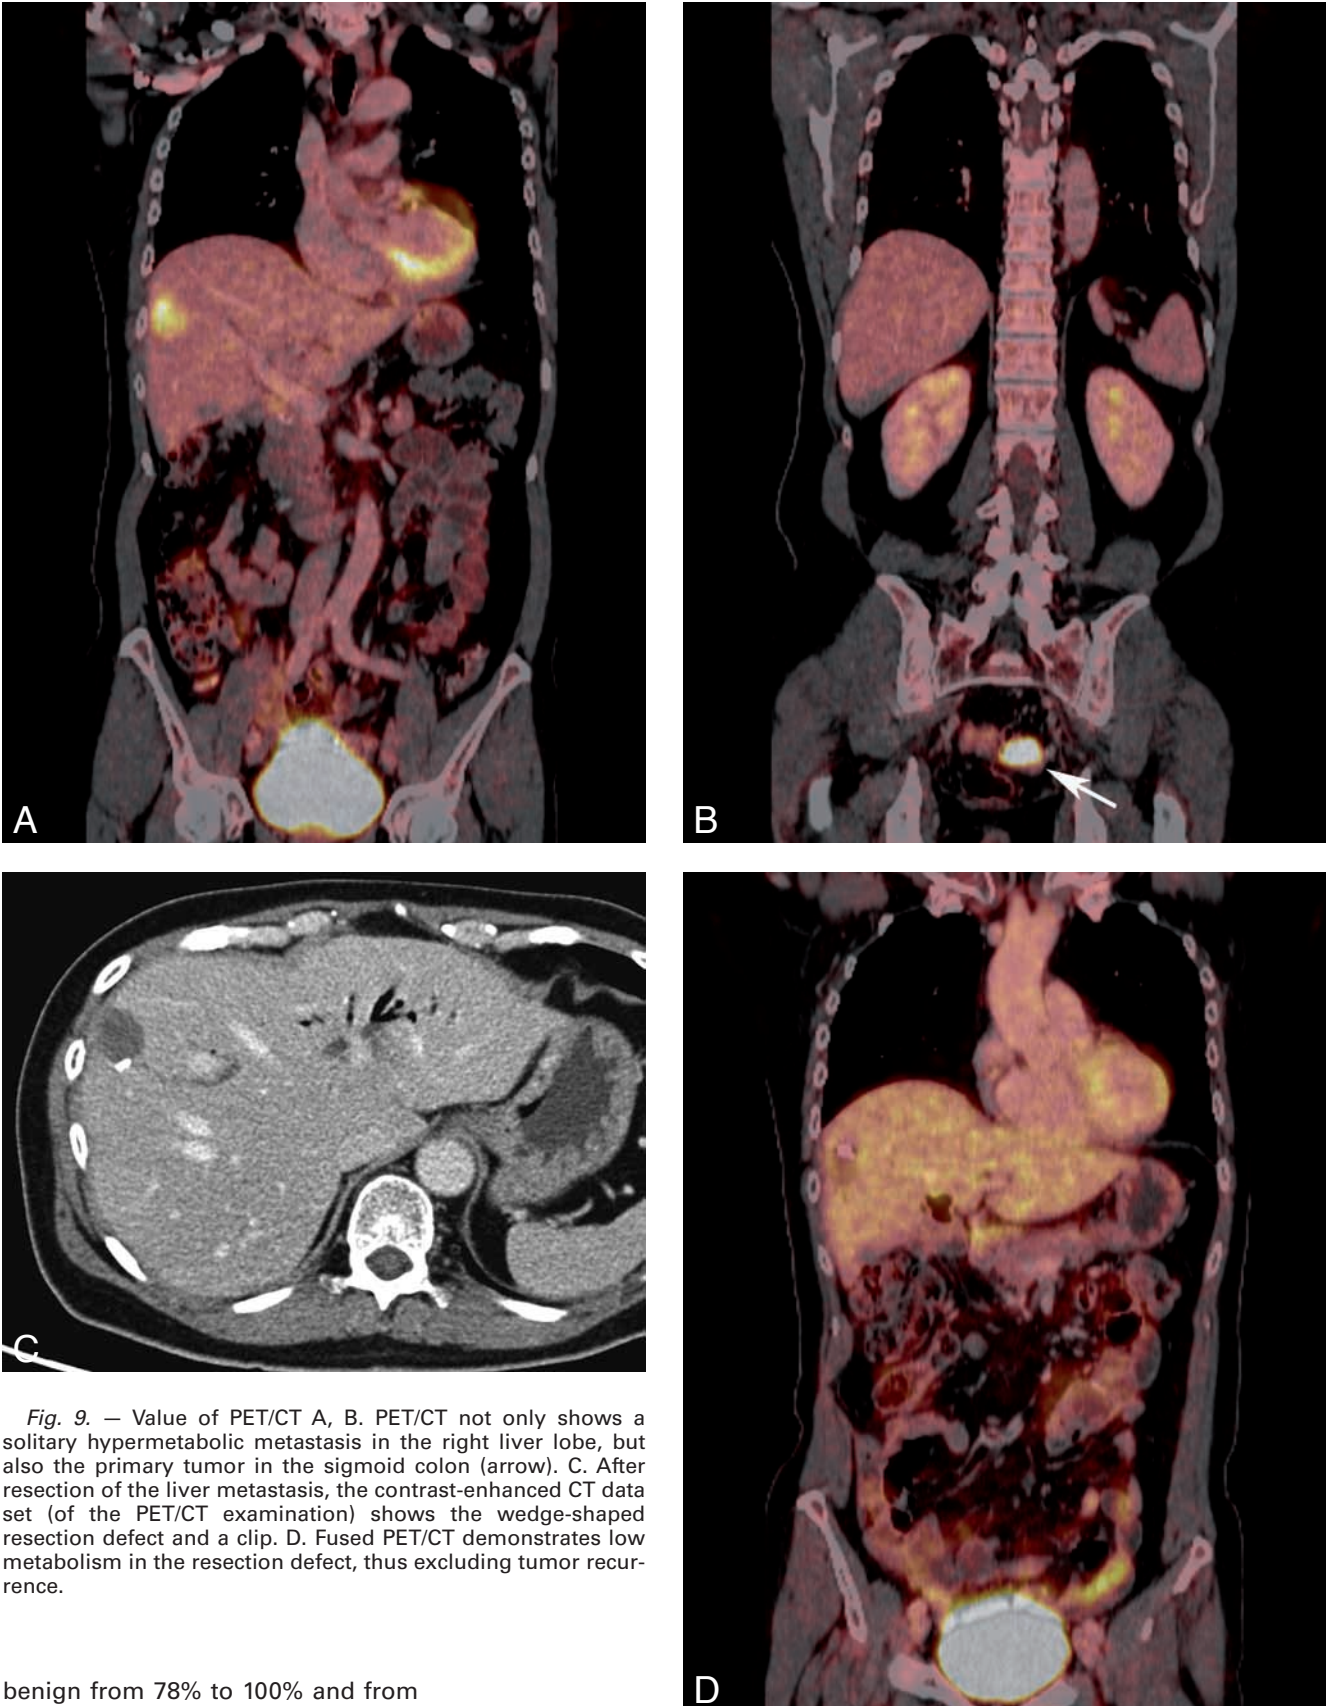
Value of PET/CT A, B. PET/CT not only shows a solitary hypermetabolic metastasis in the right liver lobe, but also the primary tumor in the sigmoid colon (arrow). C. After resection of the liver metastasis, the contrast-enhanced CT data set (of the PET/CT examination) shows the wedge-shaped resection defect and a clip. D. Fused PET/CT demonstrates low metabolism in the resection defect, thus excluding tumor recurrence.
